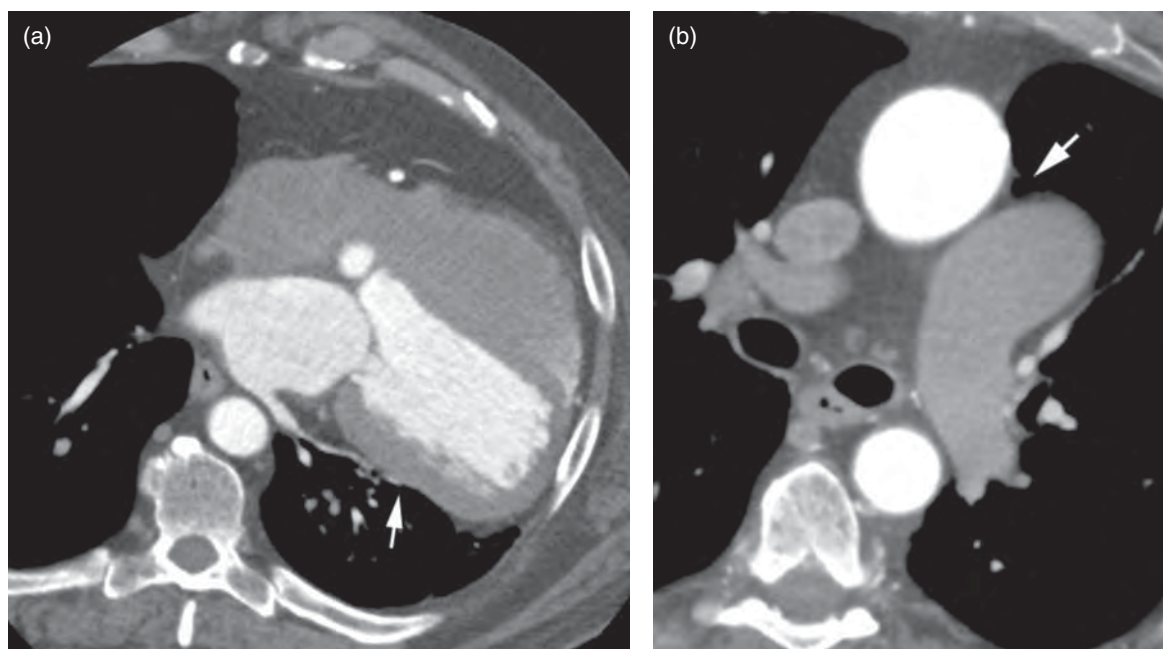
Computed tomography of the chest. (a) Scan demonstrating marked deviation of the heart into the left chest with indentation of the left ventricle secondary to the pericardial defect (arrow). (b) Short-axis image at the level of the pulmonary artery demonstrating typical interposition of the lung between the pulmonary artery and the aorta (arrow).
